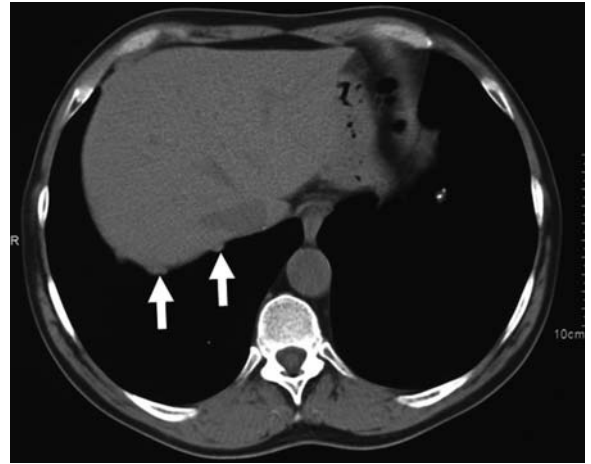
Computed tomography scan of the chest shows diaphragmatic pleural plaque appearing as small masses of soft tissue attenuation (*arrows*)
